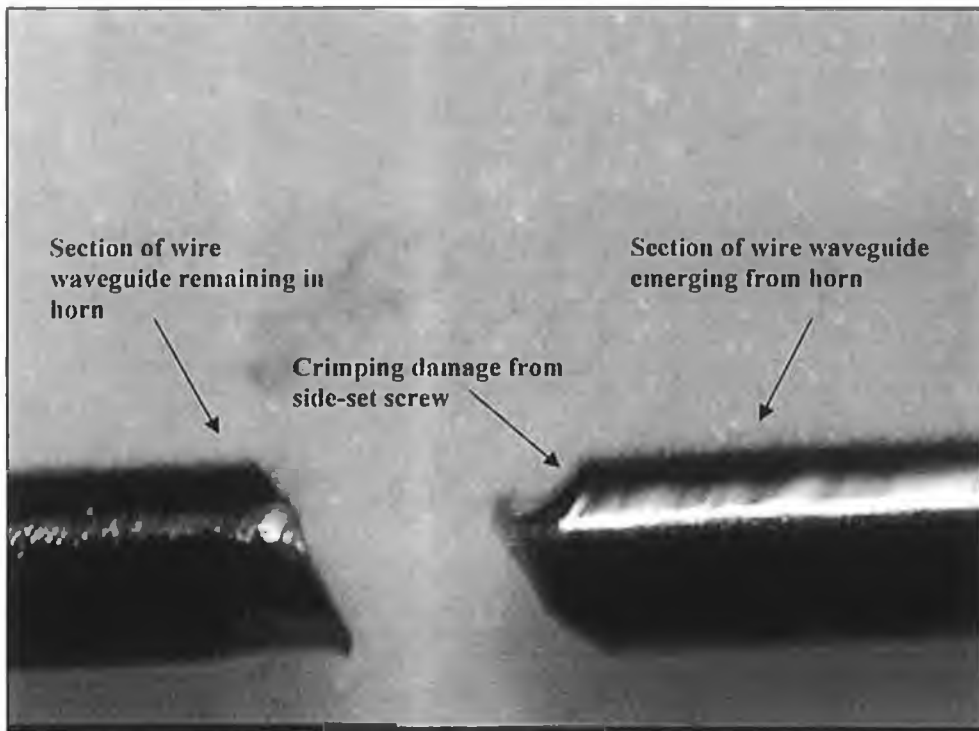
Image of failed 0.6mm wire waveguide following application of ultrasound.
